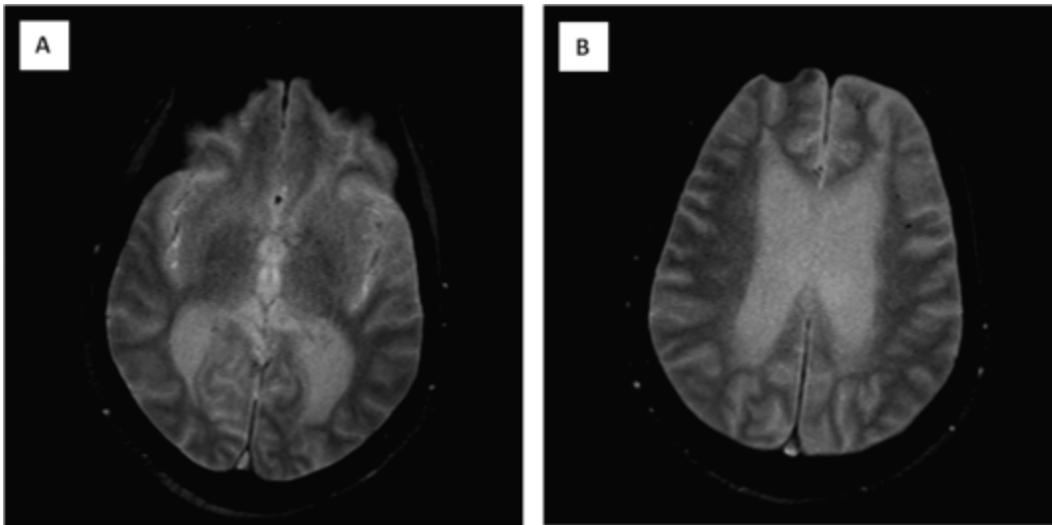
Select gradient echo (GRE) brain MR images obtained four days after presentation.
